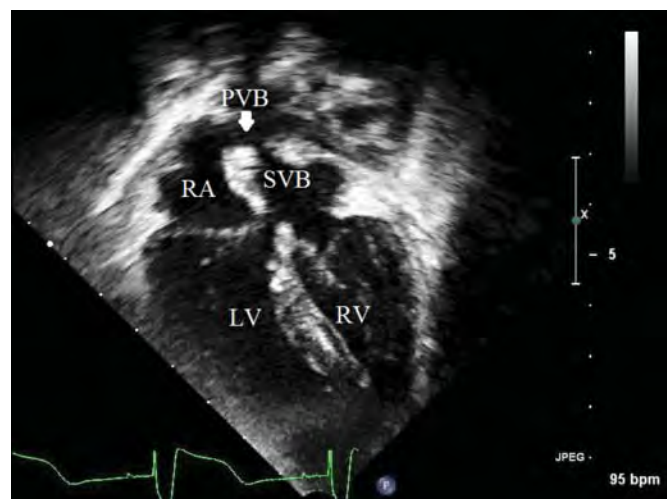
A 2D echocardiography apical four-chamber view. The atrial switch component of the double switch procedure is detailed: note the pulmonary venous baffle cascading over the systemic venous baffle toward the right atrium and right-sided morphologic left ventricle. Systemic venous blood is baffled right to left toward the morphologic right ventricle. LV, left ventricle; PVB, pulmonary venous baffle; RA, right atrium; RV, right ventricle; SVB, systemic venous baffle.
